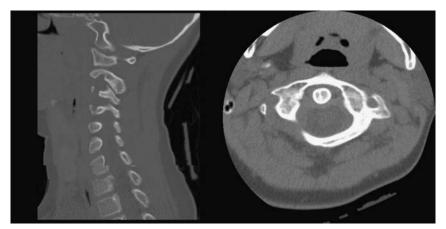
Sagittal and axial CT scans with return of normal alignment and rotation after treatment with conservative therapy.
